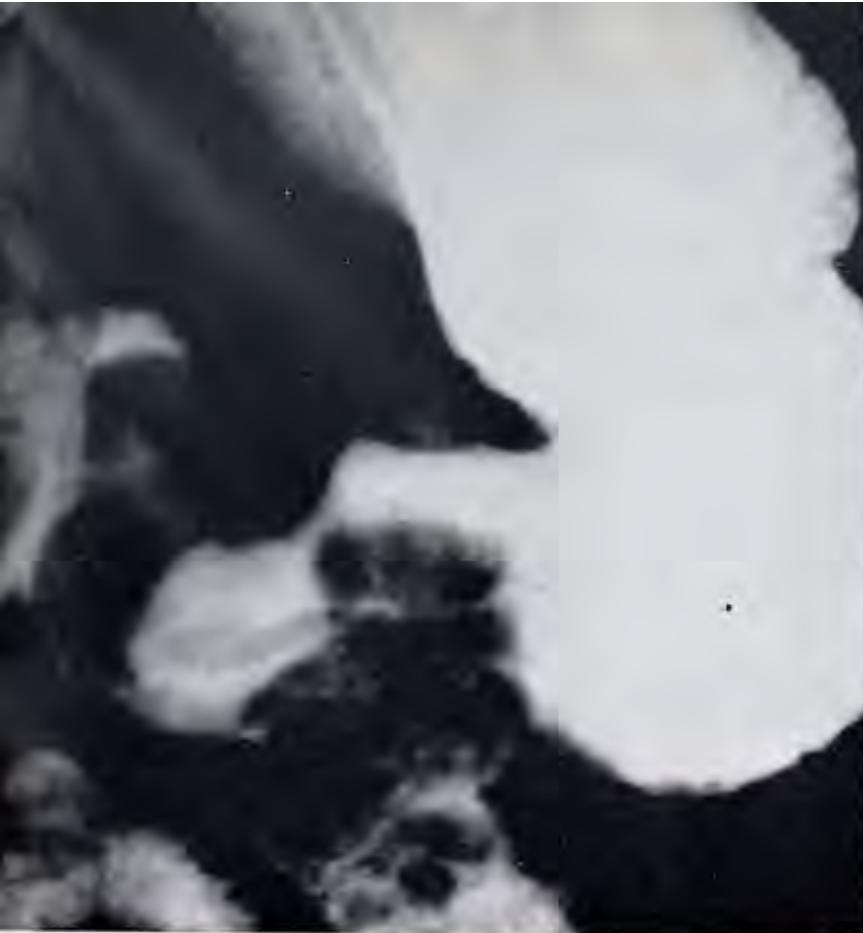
Roentgenogram showing extensively ulcerated, lobulated, intraluminal mass in the gastric antrum.
